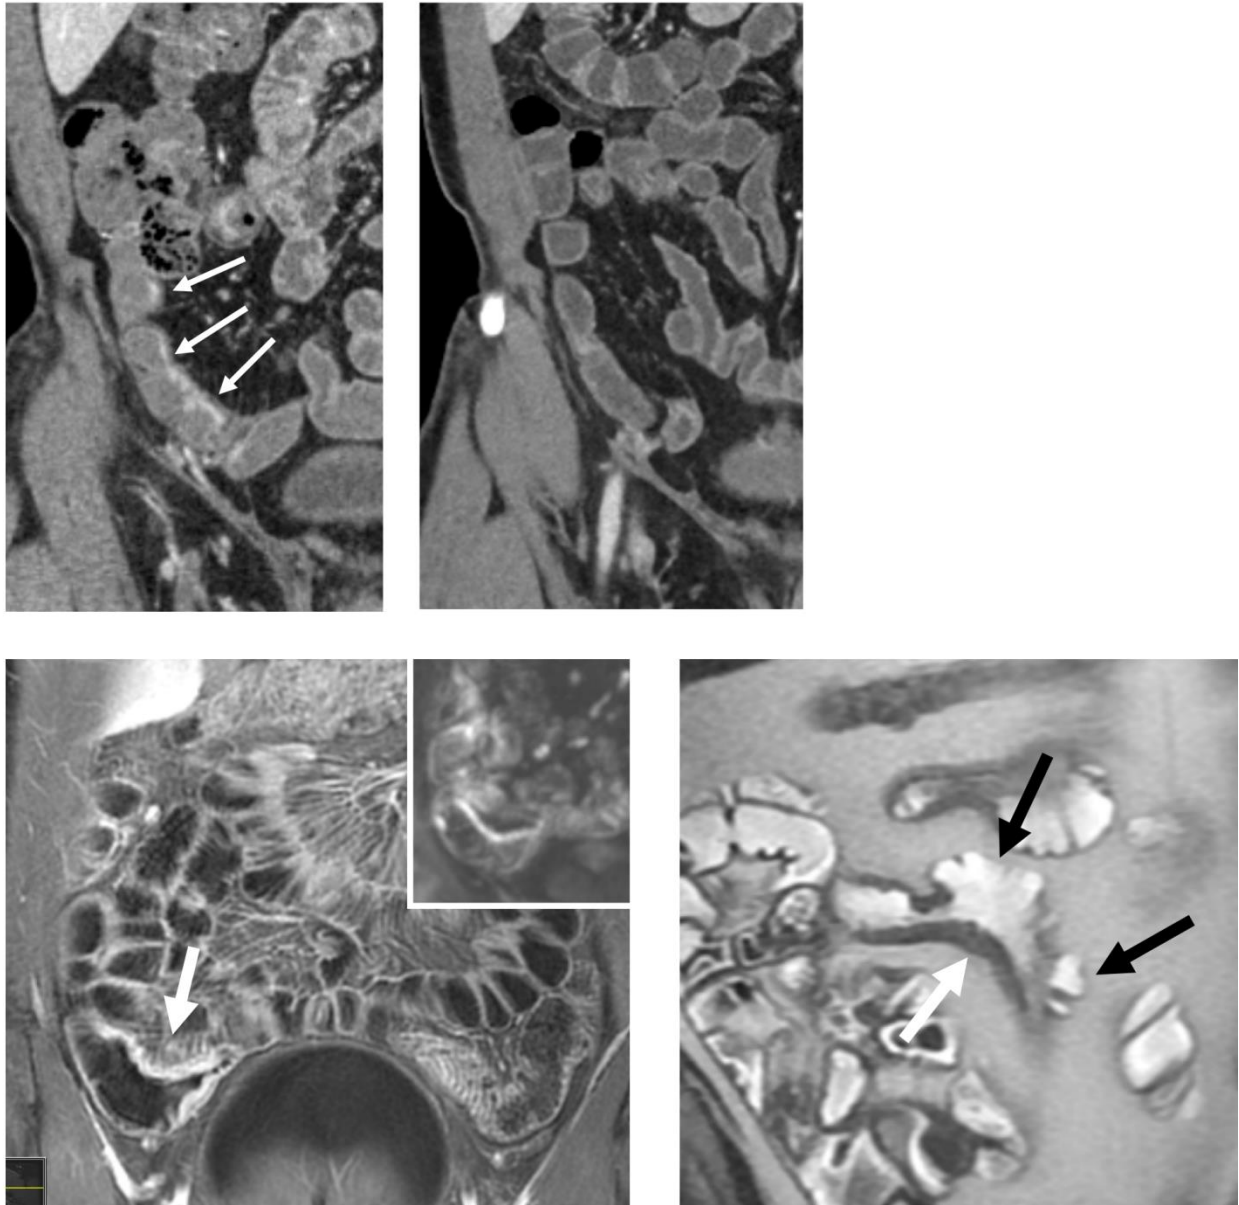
Imaging findings of severe small bowel inflammation at MR and CT enterography in three different patients. Top row shows substantial wall thickening, intramural edema on T2-weighted fat-saturated image, restricted diffusion, and small ulcerations on gadolinium enhanced images. Middle row shows findings of inflammation with wall thickening with ulcerations, intramural fat on enteric phase imaging indicating chronicity, and persistent layered enhancement indicating active inflammation on delayed imaging. Bottom row shows CT enterography images demonstrating severe inflammation with marked wall thickening and ulcerations (bottom row, white arrows).
